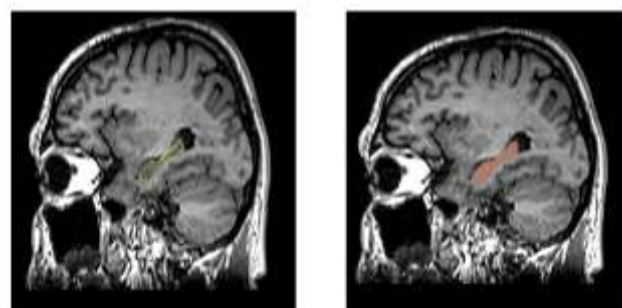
Normal T1-weighted coronal and sagittal MRI of brain showing outlines of the hippocampus.
